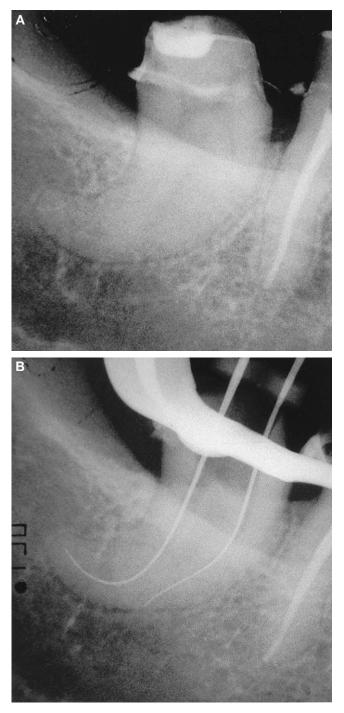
Tooth No. 32 with severe canal curvature. (A) Preoperative radiograph. (B) Working length radiograph. (C) Postoperative radiograph.
